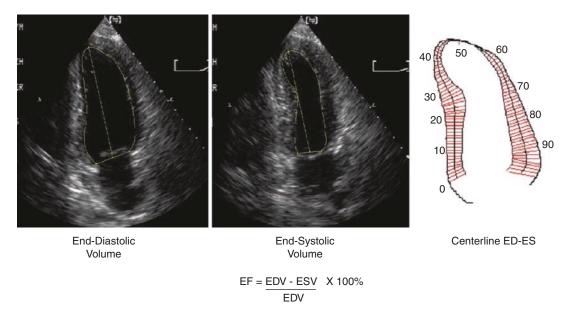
Quantitative 2-D echocardiographic evaluation of volumes and ejection fraction
